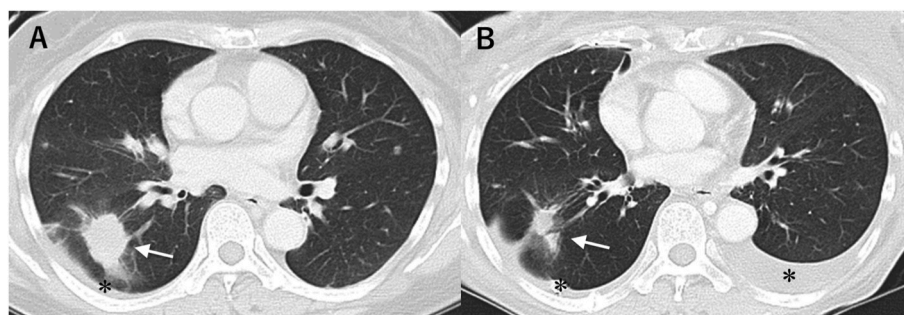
Chest CT findings at the time of diagnosis (A) and on admission (B). The patient's lung cancer (white arrow) had markedly reduced but her pleural effusion (*) remained.
